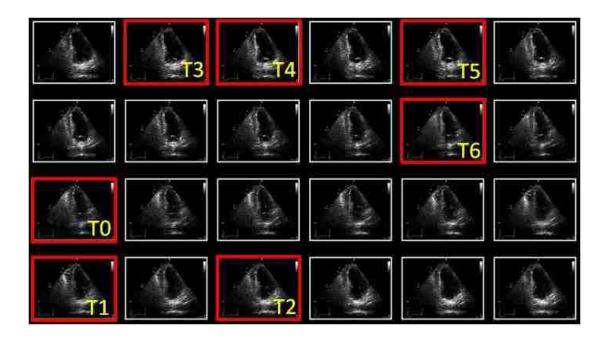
Shows selected individual steps of echocardiography
